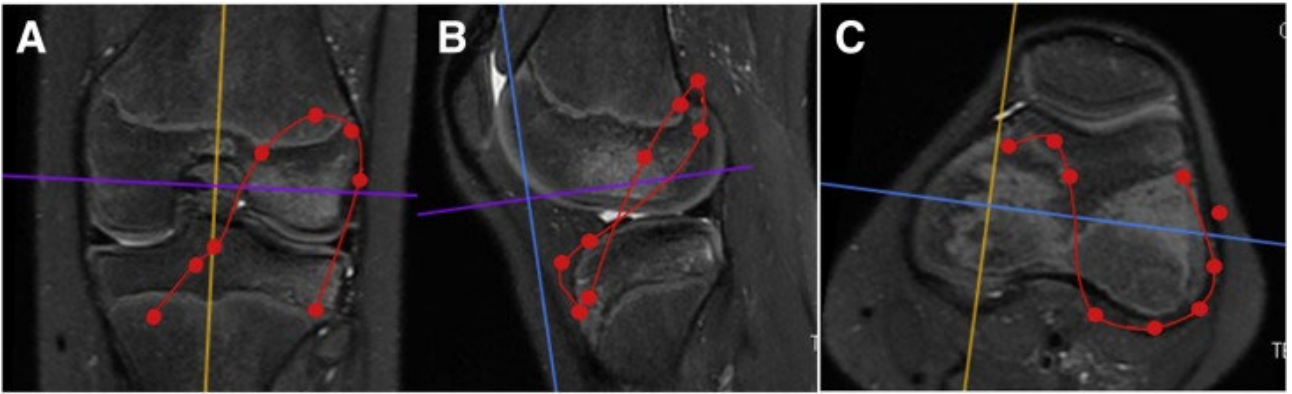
Three-dimensional (3D) measurement of the Kocher-Micheli technique on 3D magnetic resonance imaging sequences of a left knee. (A) coronal plane, (B) sagittal plane, and (C) axial plane.
